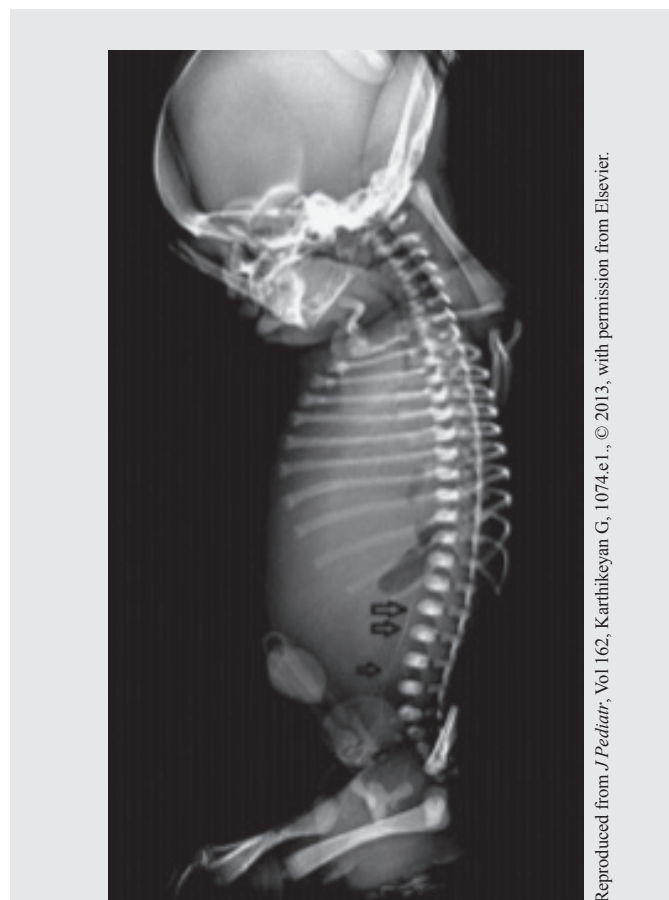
Lateral radiograph of the neonate showing calcification of descending aorta and its bifurcation (arrows).
